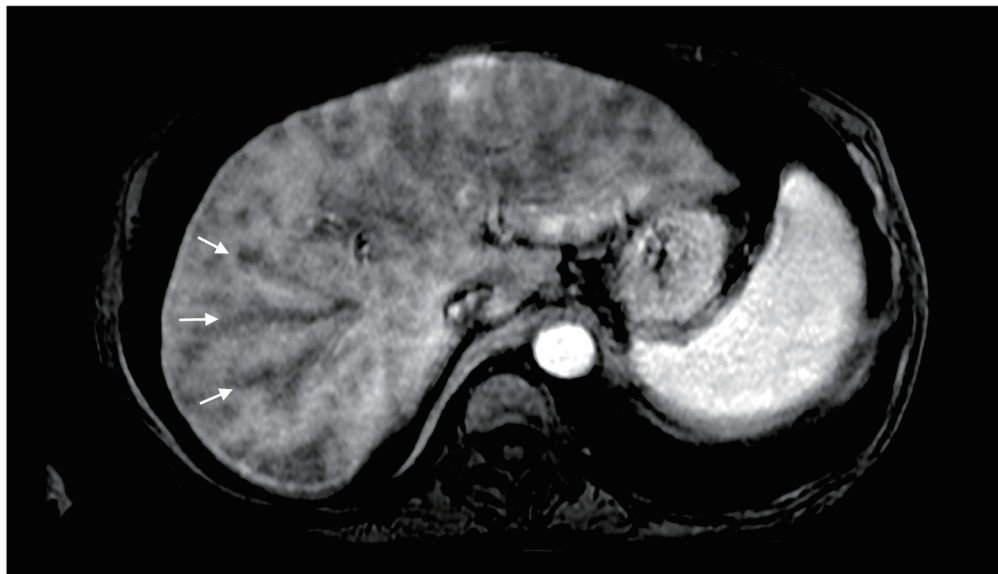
Contrast-enhanced arterial phase MRI of the liver demonstrating perivascular branching pattern (score of 5) identified by white arrow. MRI, magnetic resonance imaging.
